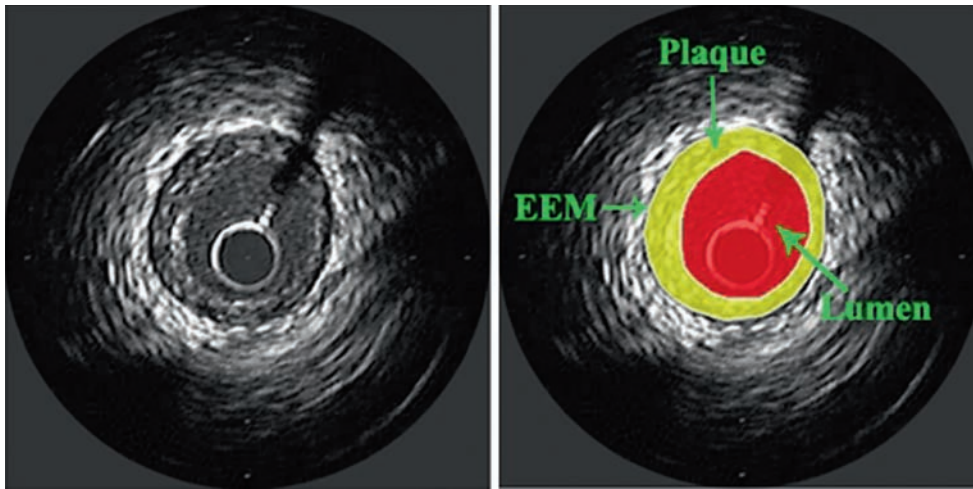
IVUS Image: An intravascular ultrasound image demonstrating the external elastic membrane (EEM), plaque, and lumen areas
